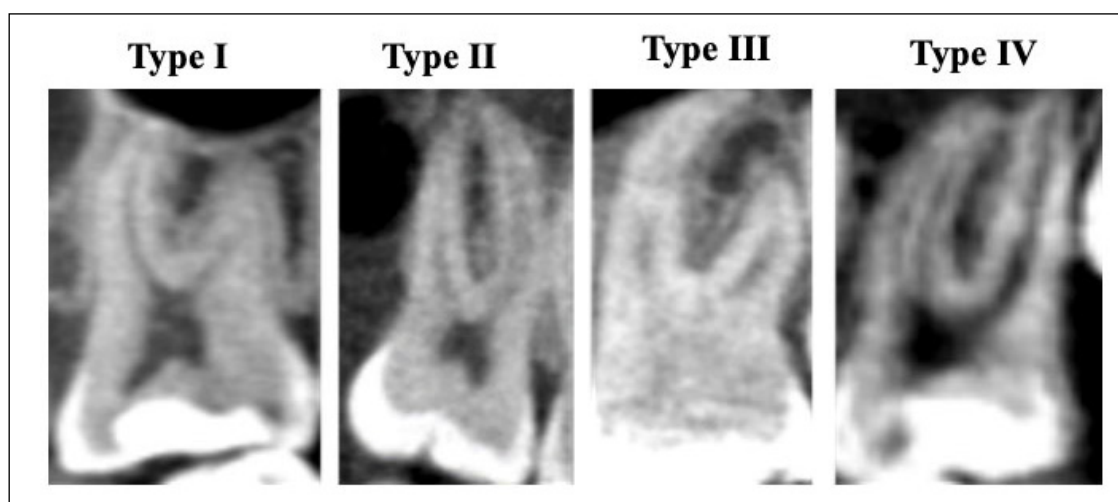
CBCT view of maxillary molars displaying different types of Vertucci canal configurations in the mesio-buccal root. Type I: originates and continues as one canal from the orifice to the apex; Type II: originates as two canals from the orifice, merges into one canal before exiting the apex; Type III: originates as two canals at the orifice, merges into one canal along its length and then again divides into two canals before exiting the apex; Type IV: originates and continues as two canals from the orifice to the apex.
